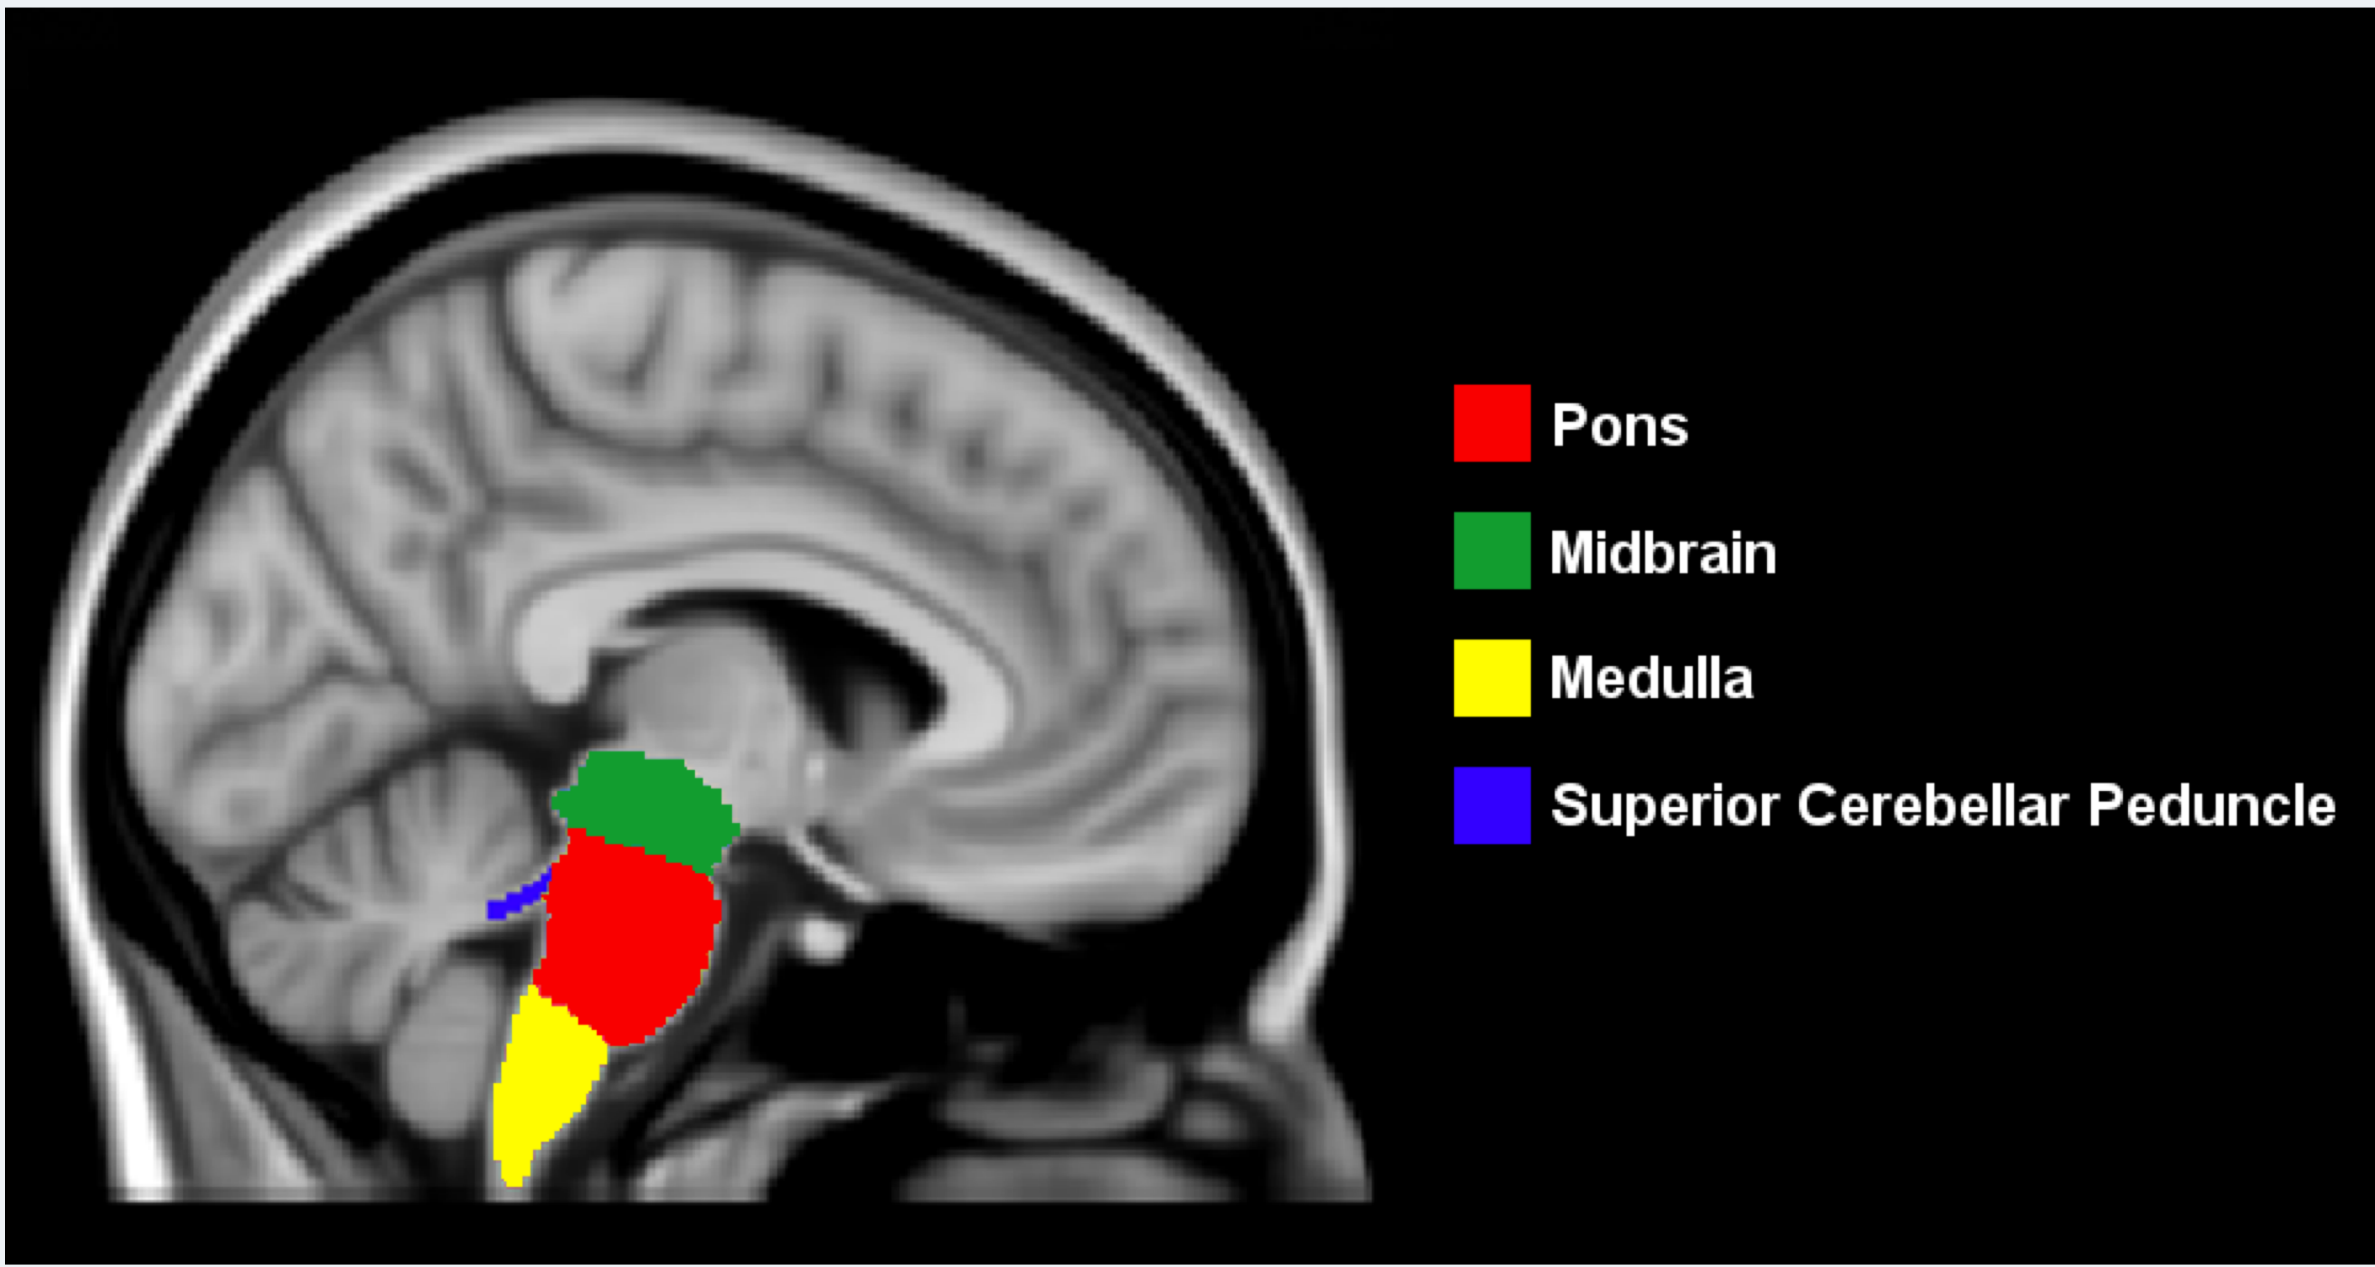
Example of brainstem segmentation mapped on the T1-weighted ICBM152 template.
